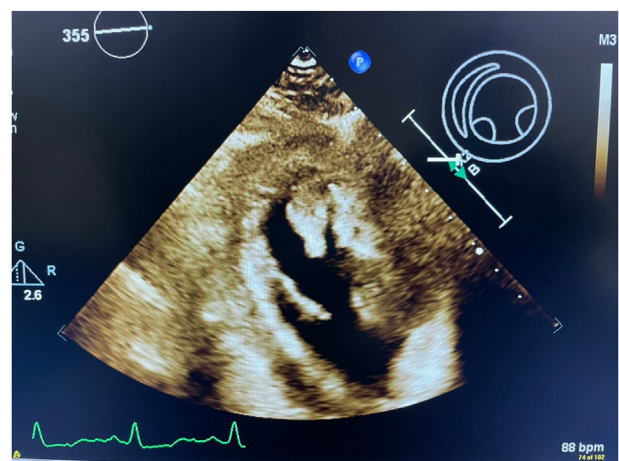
Transthoracic echocardiogram: Massive apical thrombus in the left ventricle.
